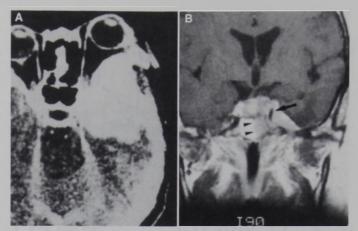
A*, Patient 1. Left sphenoid wing meningioma (meningotheliomatous meningioma) invading the orbitocavernous sinus complex. A 45-year-old woman complained of exophthalmos without extraocular palsy. She was operated on; the orbitozygomatic approach was used. The cavernous apex was invaded by the tumor but was not opened so that orbital function could be preserved. *B*, coronal magnetic resonance imaging 3 years after the operation. Tumor regrowth was seen in the cavernous apex with encasement of the carotid artery (*arrow*) and with extension into the sphenoid sinus (*arrowheads*). Radical subsequent operation, including amputation of the carotid artery and the extraocular nerves, was necessary.
